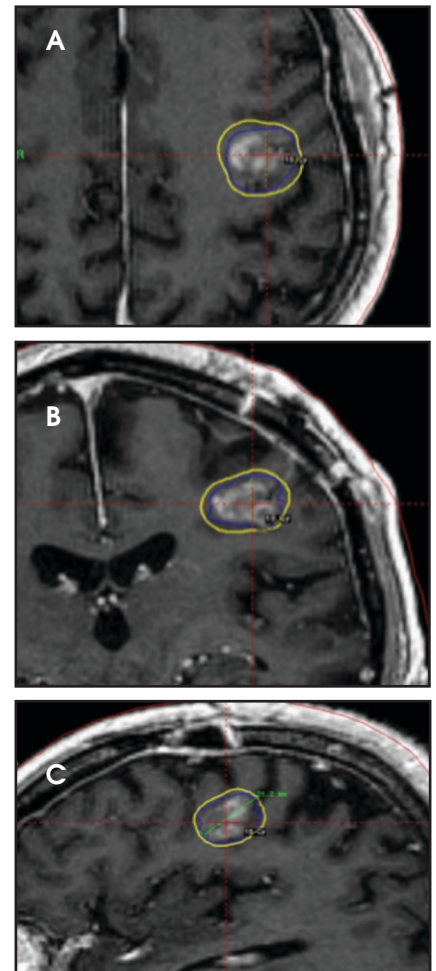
T1 MRI images with contrast completed for Gamma Knife planning in the (A) axial, (B) coronal, and (C) sagittal views showing the gross tumor volume (GTV) (blue) and the dose coverage of the planning target volume (PTV) by the 18 Gy isodose line.
